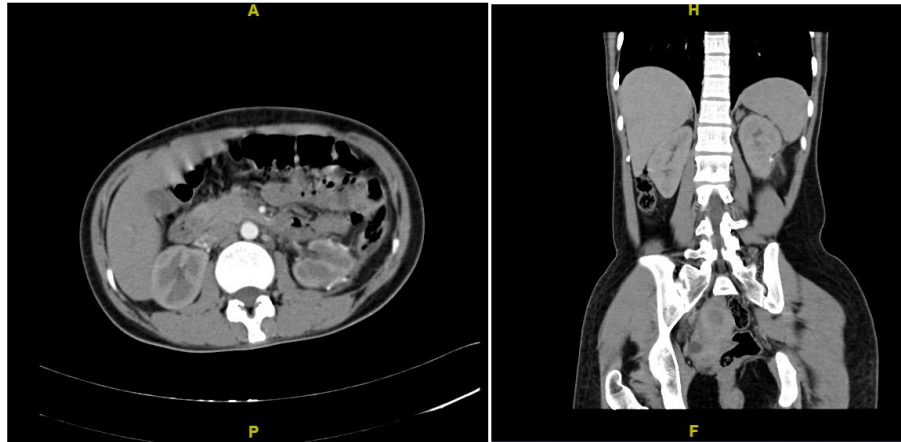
Follow-up contrast enhanced CT scan at 12 months showing no evidence of recurrence.
